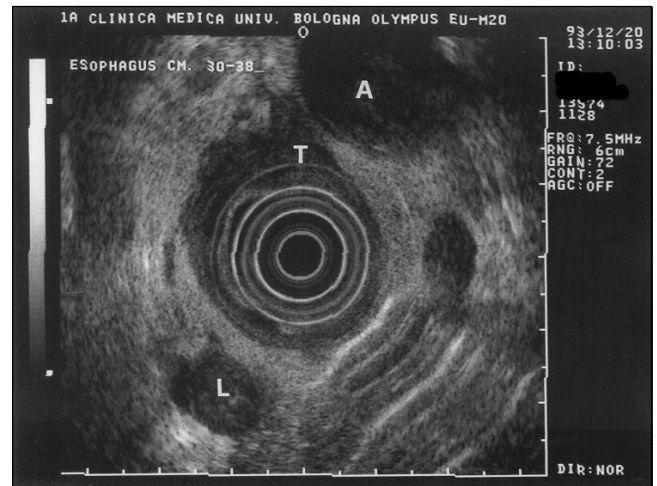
Endoscopic ultrasonography (EUS) radial scanning at 12 MHz of a T3 esophageal cancer. The tumour (T) is seen as a hypoechoic mass initially invading the adventitia. A Aorta; L Lymph node
